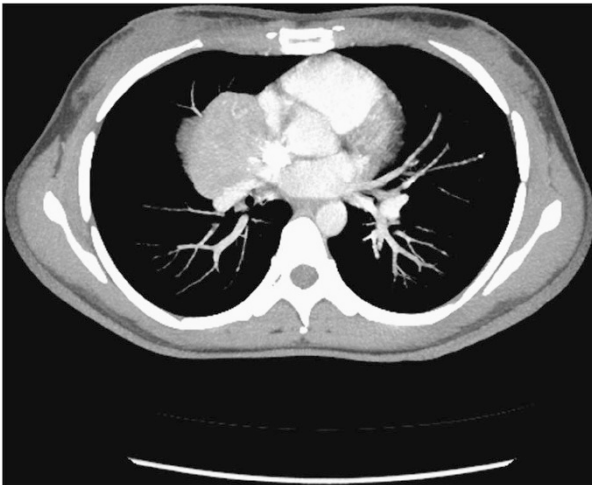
CT thorax demonstrating mediastinal mass.
